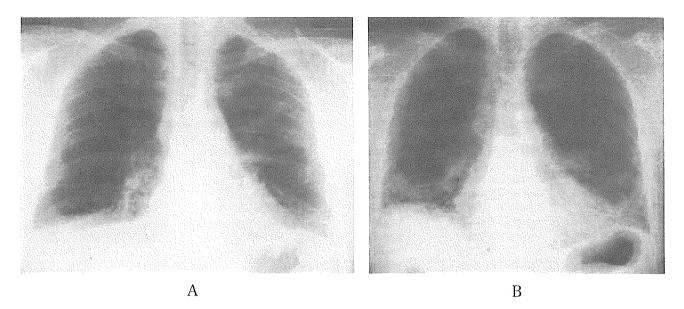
Chest X-ray (A, April 1997 (on admission); B, May 2004). A: On admission, reduced volume of bilateral lungs, and elevation of diaphragm was observed. B: During the follow-up period of seven years, linear and reticular shadows developed in the bilateral lower lungs, however, the lesions were minimal in the upper and middle lung fields.
